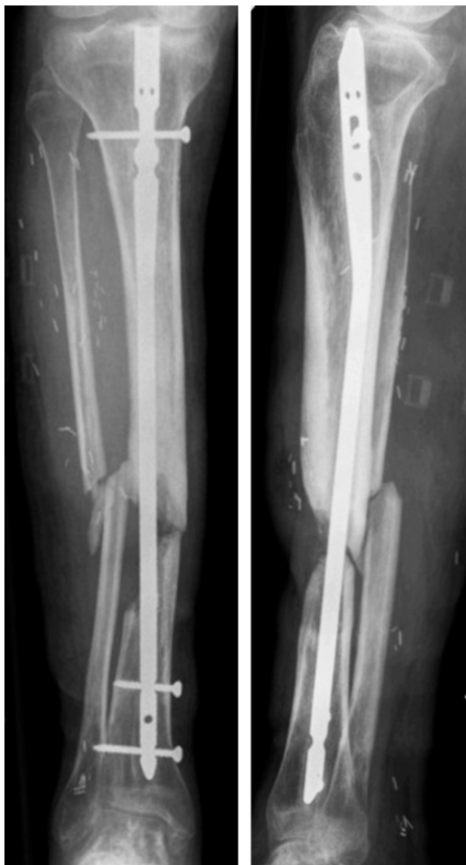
Radiograph in anteroposterior (left) and lateral (right) view of avascular non-union sixteen months after initial injury.
